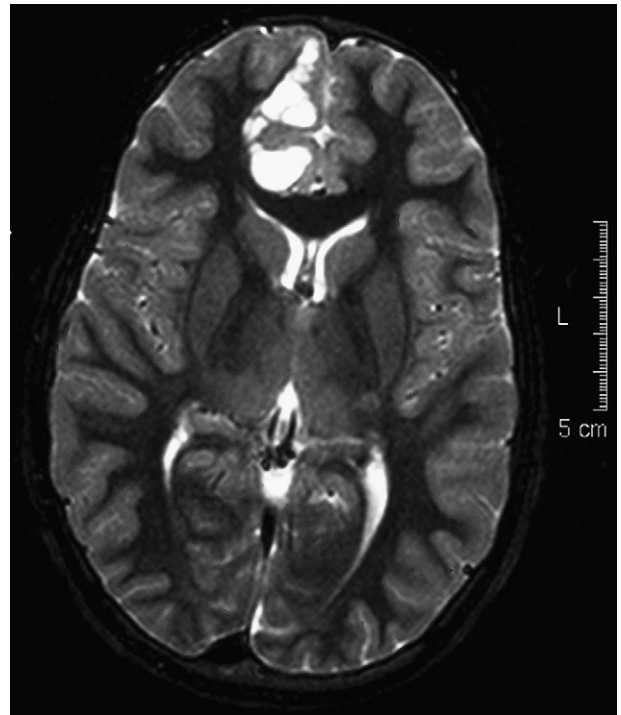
Axial T_2 -weighted magnetic resonance image (TR/TE = 4427/100 ms). Multiple cortical and subcortical cysts are seen. Note pressure on and distortion of the adjacent cortex, without any surrounding edema.
